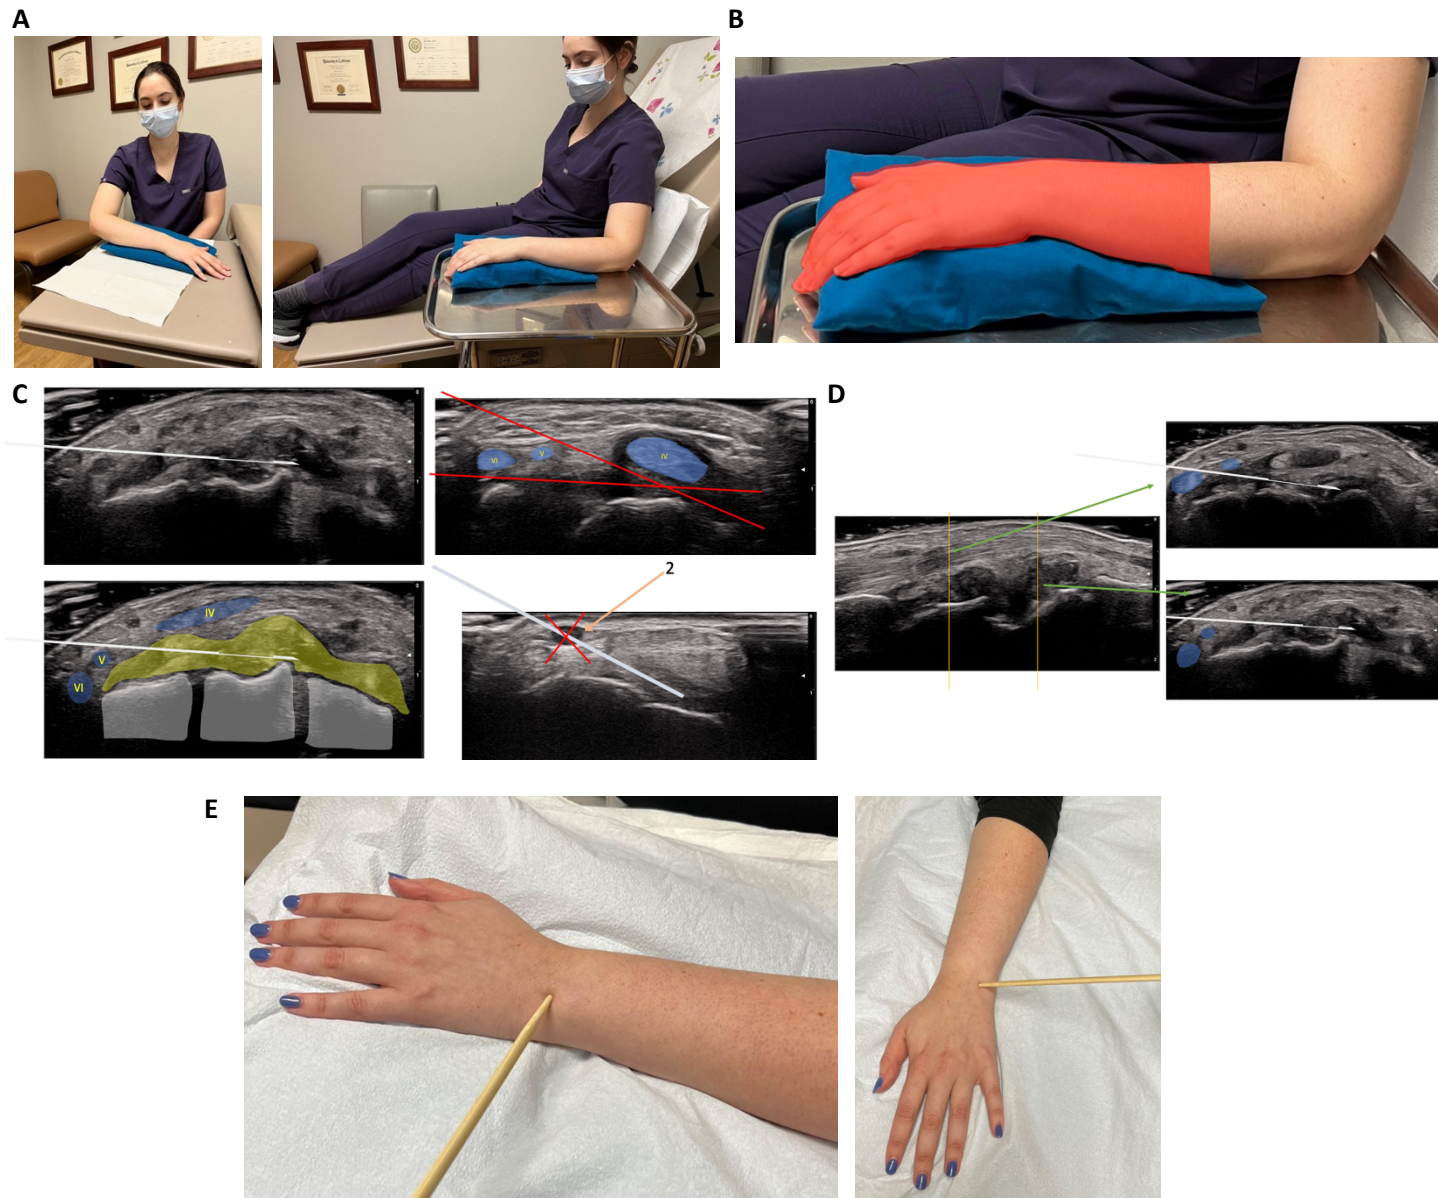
Ultrasound-guided wrist biopsy
